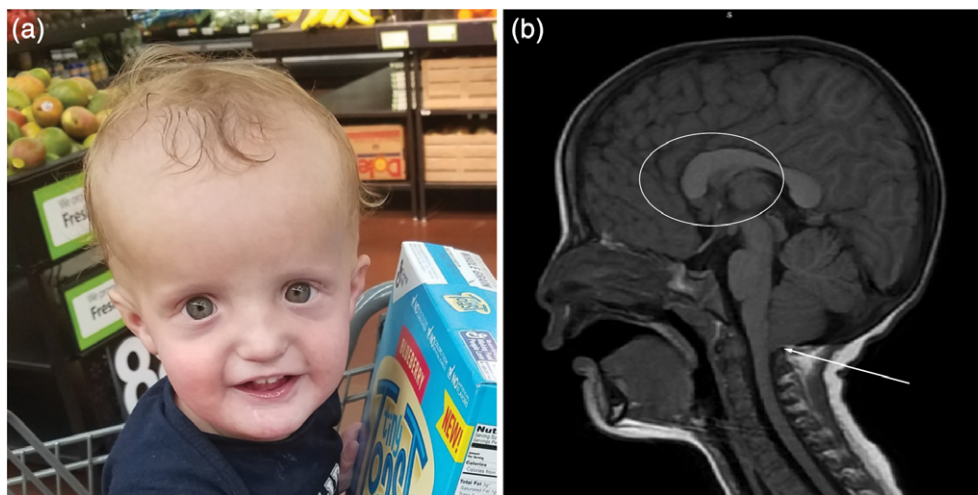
Patient phenotype. (a) a photograph of the boy at age two demonstrates relative macrocephaly, a triangular face, widely spaced eyes, downslanted palpebral fissures, malar flattening, and a thin vermilion of the upper lip. (b) MRI at 20 months of age shows abnormalities that include a thickened corpus callosum, especially at the genu and splenium (white circle), a mild Chiari I malformation (white arrow), and a shallow Sella turcica with a flattened pituitary gland [Color figure can be viewed at wileyonlinelibrary.com]
